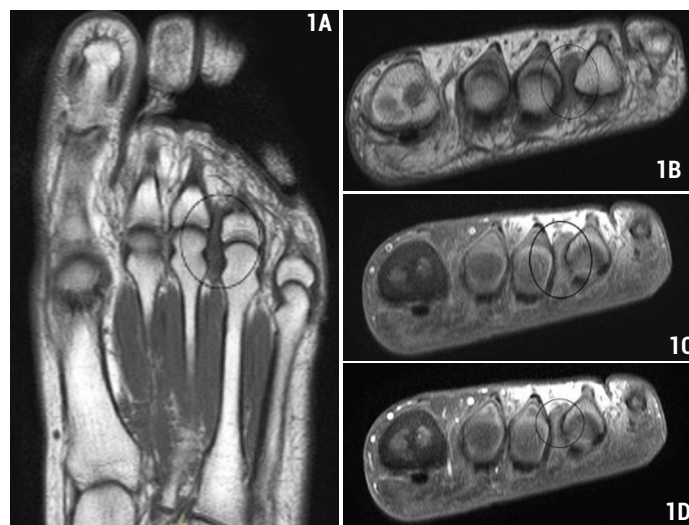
40-year-old woman with surgically proven Morton's neuroma. Transverse T1-weighted (1A), oblique coronal T1-weighted (1B) and oblique coronal fat-suppressed T1-weighted (1C) MR images show well-demarcated soft-tissue mass (circle) isointense to muscle in third intermetatarsal space. Oblique coronal fat-suppressed contrast-enhanced T1-weighted (1D) MR image shows mild enhancement in the soft-tissue mass
